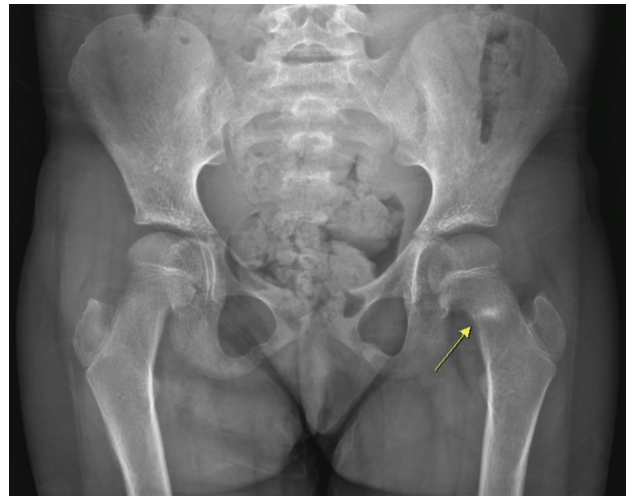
30th day clinic visit; there was callus visible on pelvic anteroposterior X-ray
